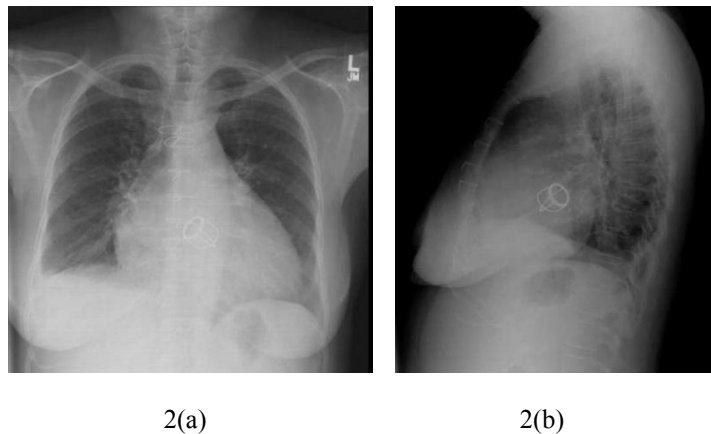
(a) Frontal and (b) lateral chest X-ray of a woman suffering from cardiomegaly [8].
